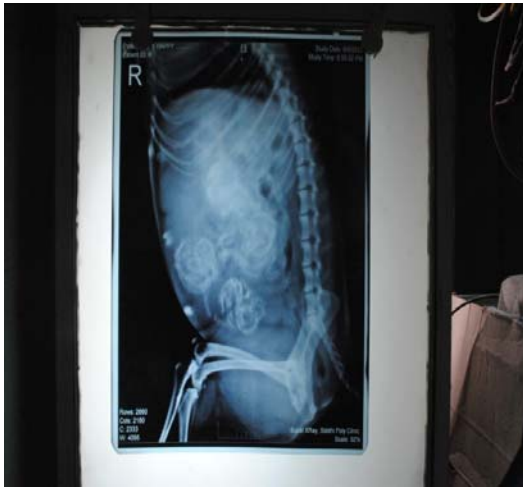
X-ray of the abdominal cavity (lateral view)
